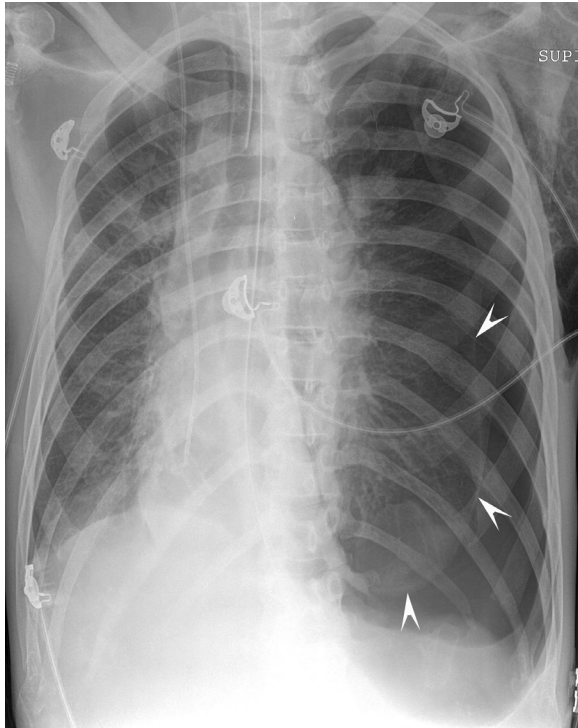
■ Anteroposterior (AP) supine chest x-ray. The left hemithorax is hyperexpanded and lucent. Left tension pneumothorax (arrowheads) accounts for these findings as well as deviation of the heart and mediastinum to the right and depression of the ipsilateral hemidiaphragm.
